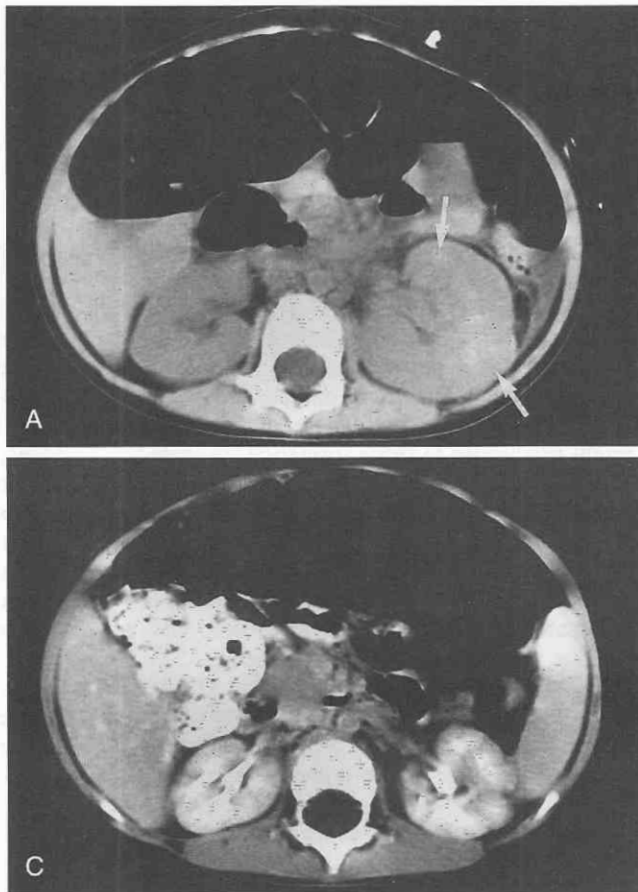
Acute hemorrhagic pyelonephritis with progression to cortical scarring in a 3-year-old girl. Cultures of both urine and blood were positive for *Escherichia coli*. A, Nonenhanced CT of the kidneys. The left kidney is globally enlarged, with subtle, irregular regions of increased parenchymal attenuation anteriorly and laterally (arrows), representing areas of intraparenchymal hemorrhage. B, Enhanced CT of the kidneys. The left kidney is globally enlarged, with multiple large, irregular, low-attenuation, nonenhancing regions anteriorly and laterally (arrows), consistent with acute pyelonephritis. C, Enhanced CT of the kidneys 2 months later. The left kidney has decreased dramatically in size. The pattern of parenchymal enhancement on the left is now more normal. However, multiple clefts are visible along the lateral margin of the left kidney, consistent with evolving cortical scars, which were confirmed by ^{99m}Tc -dimercaptosuccinic acid (DMSA) cortical scintigraphy (not shown).
